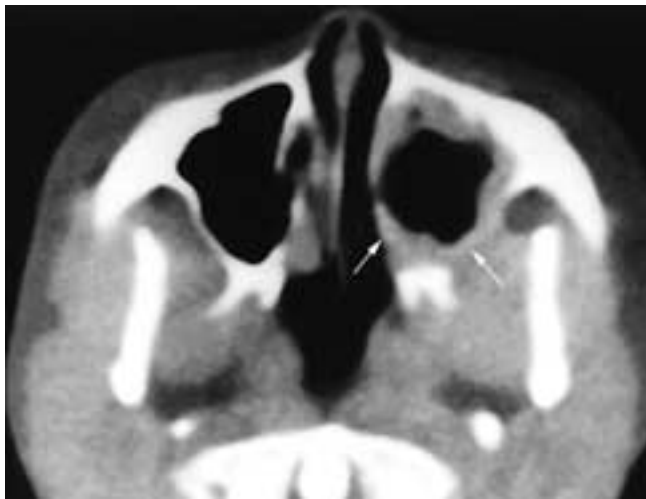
Axial CT scan performed after surgical drainage of a presumed mucocoele shows thinning or destruction of the medial and posterior antral walls (*arrows*), with fairly uniform soft tissues lining the antrum. This patient had a rare chordoma of the maxillary sinus.
